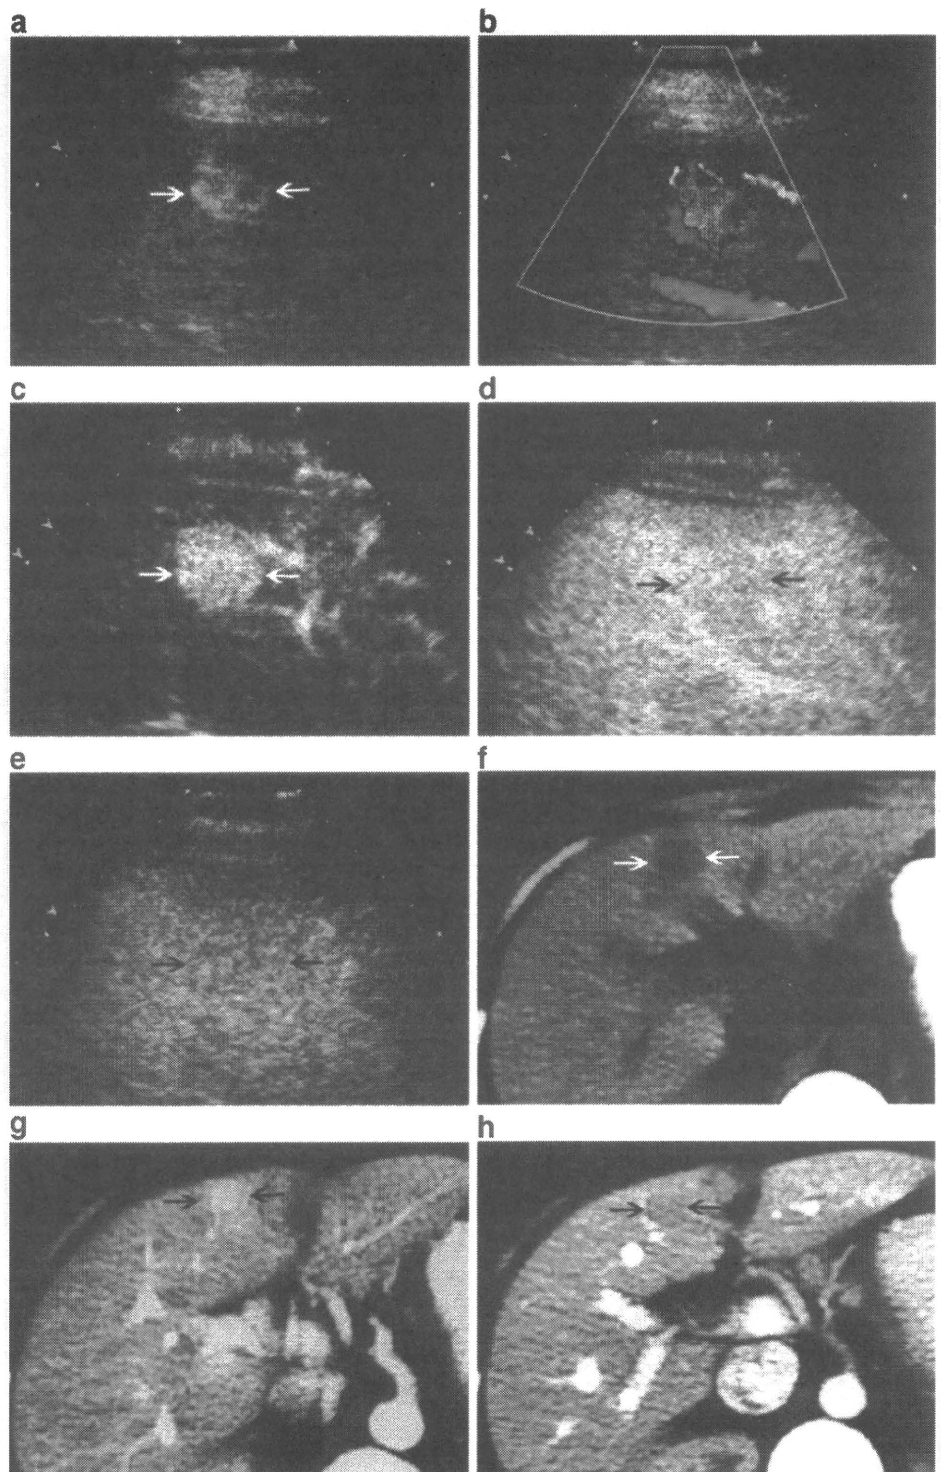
Angiomyolipoma in a 34-year-old woman. a Baseline sonography shows a hyperechoic lesion (*arrows*) sized 2.5 cm in diameter in segment 4. b Color Doppler image shows peripheral vascularity. c CEUS image with CPS technique obtained 16 s after contrast agent administration shows homogeneous hyperenhancement of the lesion (*arrows*). d CEUS image obtained 57 s after contrast agent administration shows homogeneous iso-enhancement of the lesion (*arrows*). e CEUS image obtained 180 s after contrast agent administration shows homogeneous iso-enhancement of the lesion (*arrows*). f CT plain US study shows a low attenuation lesion in segment 4 (*arrows*). g Arterial phase of contrast-enhanced CT shows hyperenhancement of the lesion (*arrows*). h Portal phase of contrast-enhanced CT shows iso-enhancement of the lesion (*arrows*)
